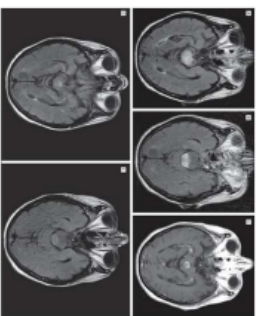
Representative image of BBE in an 81-year-old patient of MRI with FLAIR (A-B) and T1 (C). Treatment with steroids resolved symptoms and lesions (D,E).
